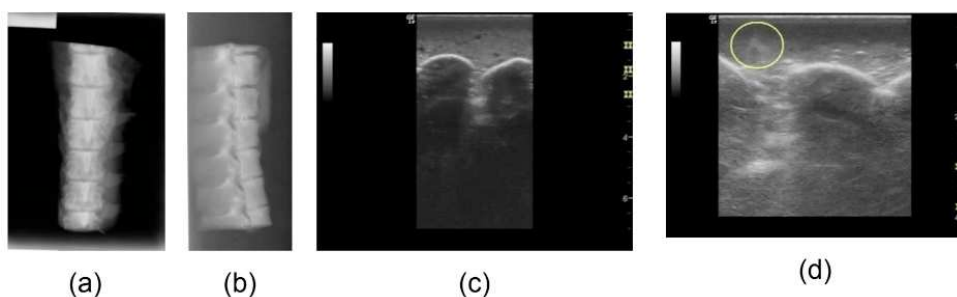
X-ray and ultrasound images in vitro from vertebrae model is presented. In (a) and (b), frontal and sagittal radiological images are observed, respectively. In (c) and (d), there are ultrasound images; and, (d), a dynamic anomaly shows the insertion of the needle.
